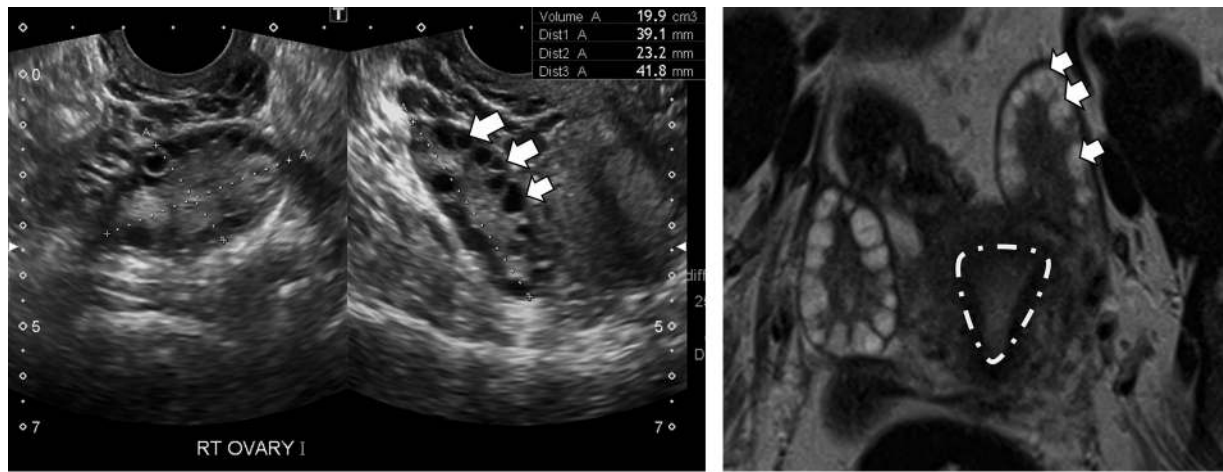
PCOS in a 30-year-old woman. US (a) and axial T2-weighted MR (b) images show the typical morphology of polycystic ovaries. The large-volume ovaries contain multiple small follicles (arrows) arranged along the periphery with no dominant follicle. The MR image also shows the normal uterine cavity (dashed line).
